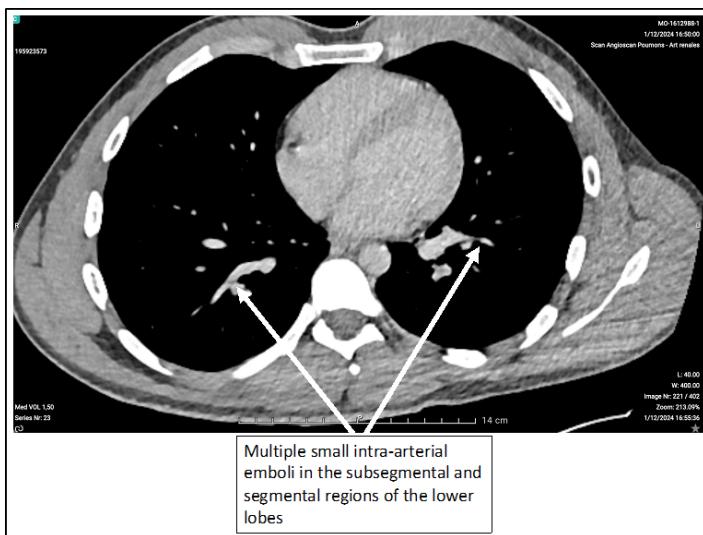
CT angiography showing small intra-arterial emboli of the lower lobes.
